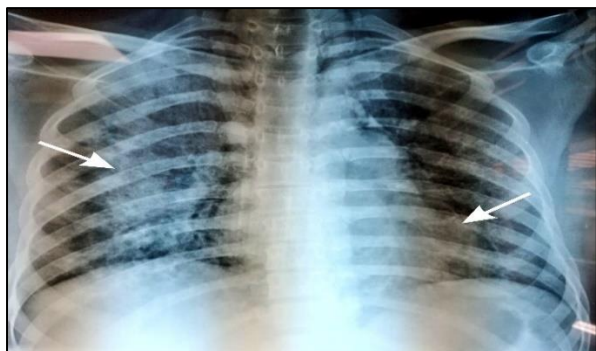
The chest X-ray on I-day (admission) showed minimal bilateral infiltrates.
